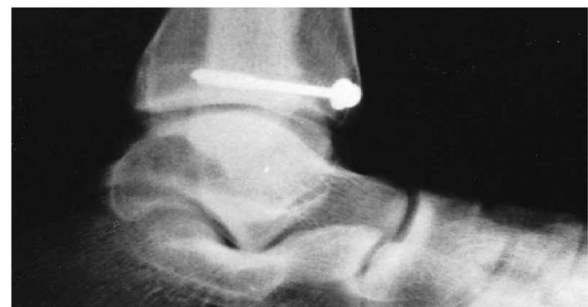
One year post-operative lateral X-ray view showing proper union without arthrosis.
